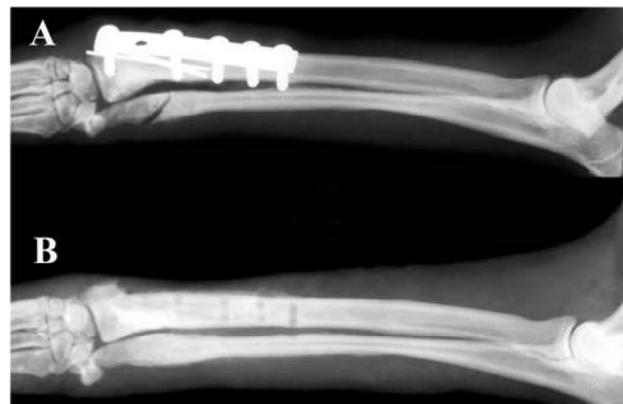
A. Roentgenogram showing correction of the angular deformation of radius and ulna, and maintenance of the separation between the radius and ulna. B. Roentgenogram of the case obtained at the fourth month post-operation after fixation apparatus were removed. Complete recovery is showing.
